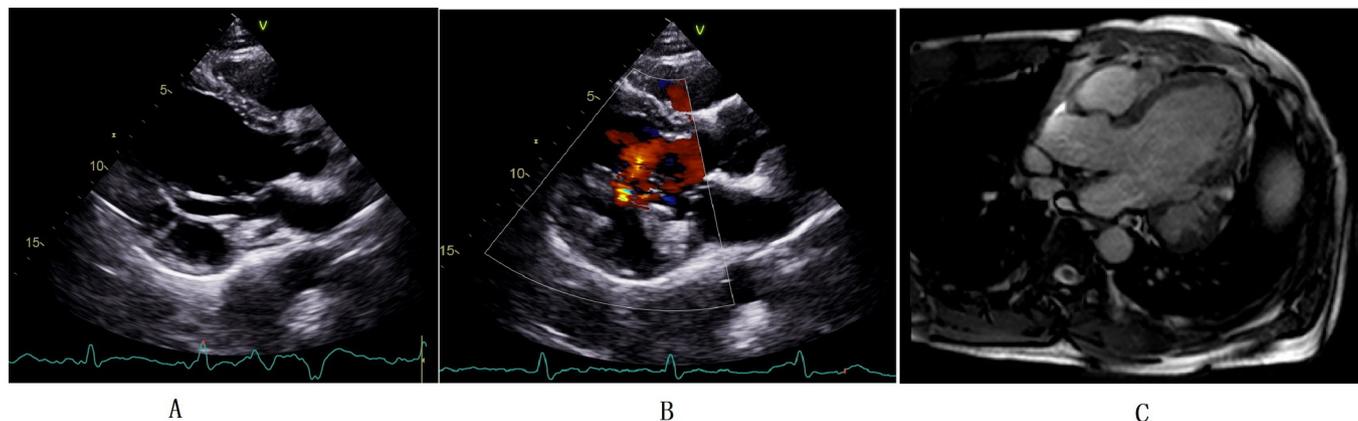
Transthoracic echocardiography (TTE) and cardiac magnetic resonance (CMR). (A) Parasternal left ventricular longitudinal axis view of TTE; (B) colour Doppler of parasternal left ventricular longitudinal axis view of TTE; (C) left ventricular longitudinal axis view of CMR.
